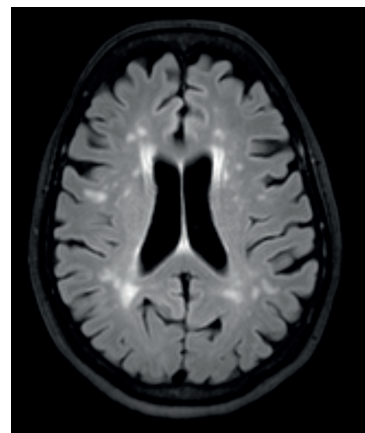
FLAIR scan showing white matter hyperintensities.
